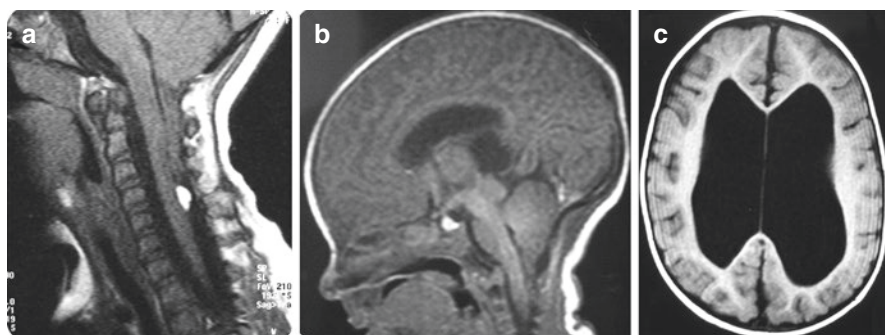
(a) Sagittal cervical T1-weighted MRI of an infant with myelomeningocele revealing the presence of Chiari II malformation and of an intradural lipoma. (b) Sagittal brain T1-weighted MRI in an infant with myelomeningocele, demonstrating displacement of the brainstem and lower cerebellum into the cervical spinal canal and the presence of a small posterior fossa, findings consisted with Chiari II malformation. (c) Axial brain MRI in an infant with myelomeningocele revealing hydrocephalus
